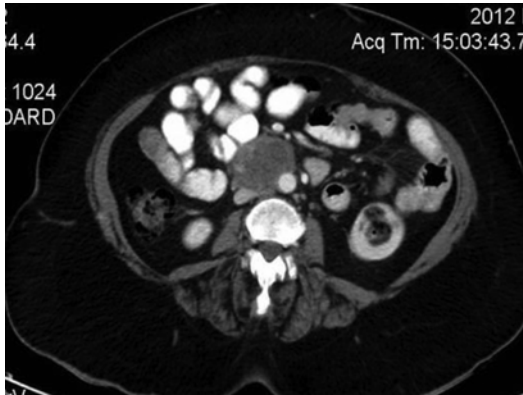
Contrast-enhanced axial CT showing heterogeneous soft tissue retroperitoneal lymph nodal mass in a case of endometrial carcinoma
